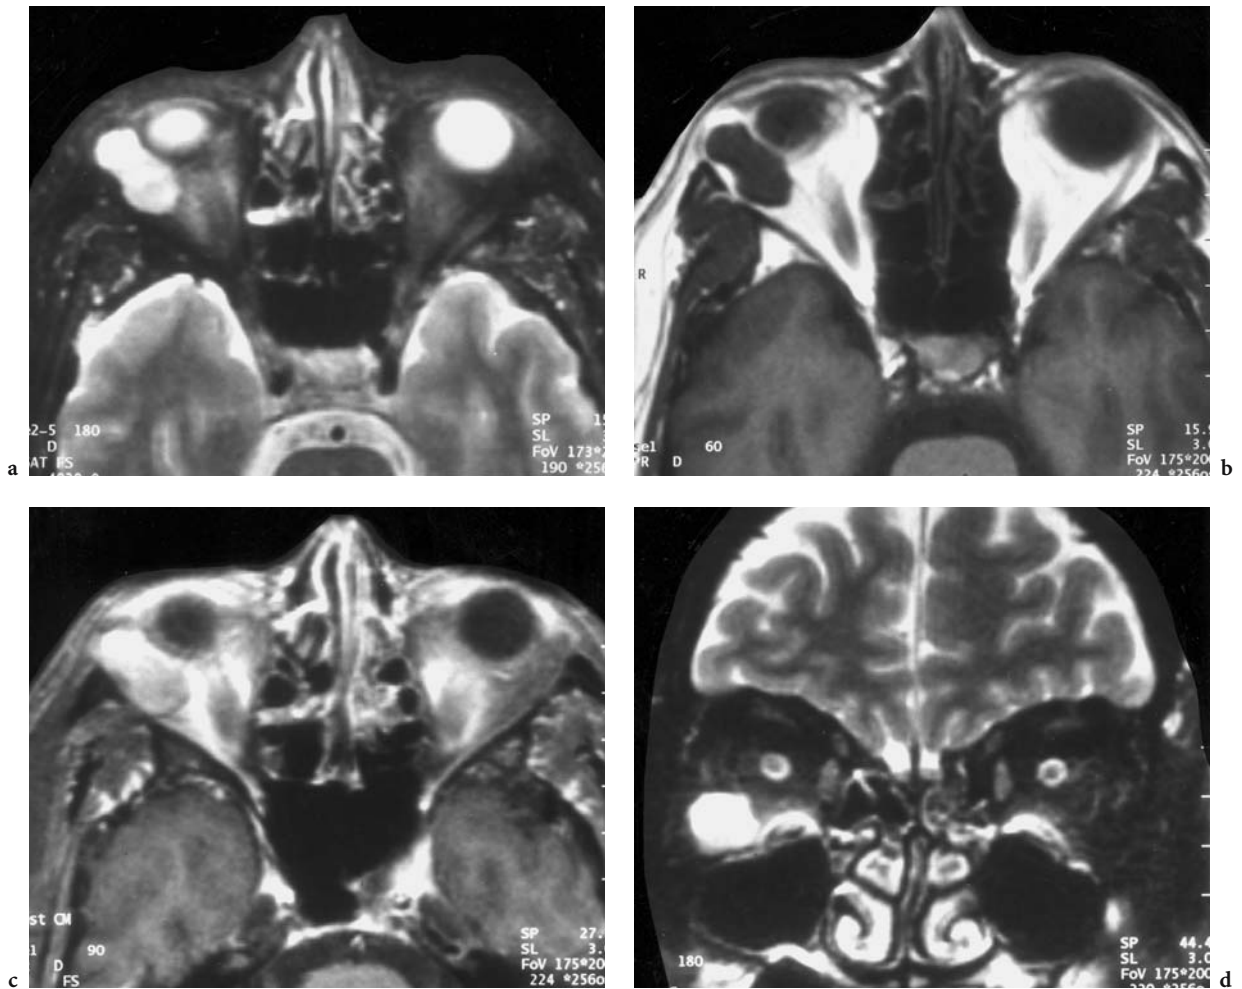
A 51-year-old woman with slowly progressing tumor of the right inferior lid. Diagnosis: hemangioma (primarily extraconal). MRI: a Axial T2-weighted view of the inferior orbit with sharply delineated hyperintense lesion of the inferior lateral orbit. b Axial T1-weighted native view of the inferior orbit with a dumb-bell-shaped, hypointense, well-defined formation lateral to the inferior rectus muscle and globe. c Corresponding T1-weighted (FS), contrast-enhanced view. d Coronal T2-weighted view visualizing the predominantly extraconal localization of the hyperintense tumor in the inferolateral orbit
